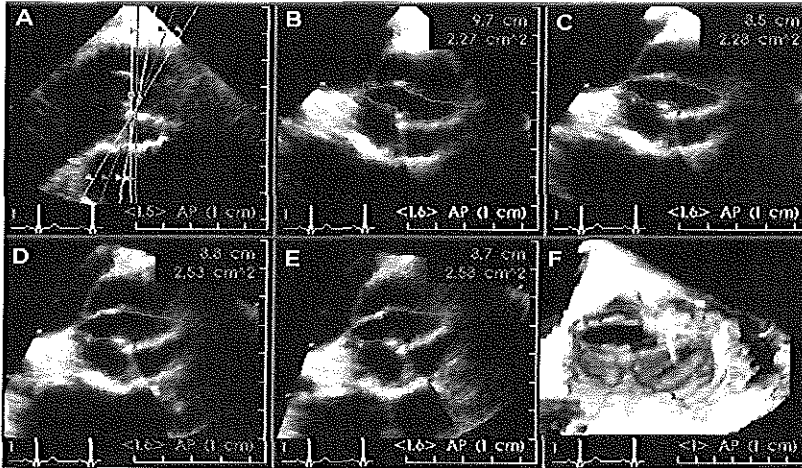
Anyplane echocardiography with three-dimensional dataset of a patient with a bicuspid aortic valve. All two-dimensional views are computer-reconstructed Optimized short-axis cross-section through the orifice at the level of cusp tips is shown in B. A displays reference long-axis image enabling placement of tangulated cutplanes (C, 10 degrees; D, 20 degrees; E, 30 degrees). F is a corresponding volume-rendered view, not used for direct planimetry with current software.
